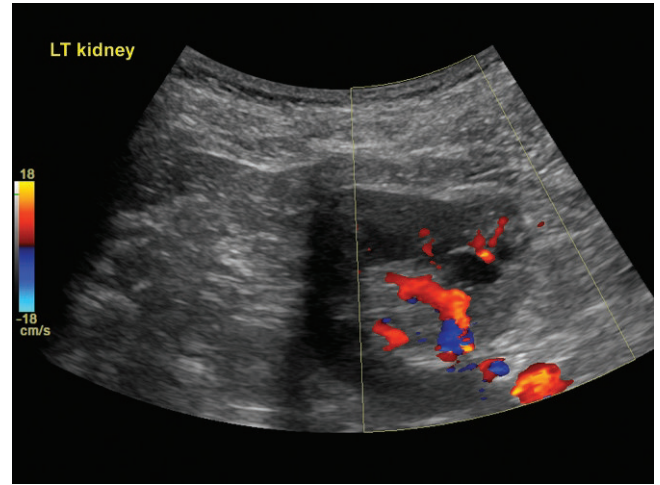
Color Doppler ultrasound demonstrates much of the mass as internal vascularity with thick septa and solid components.
